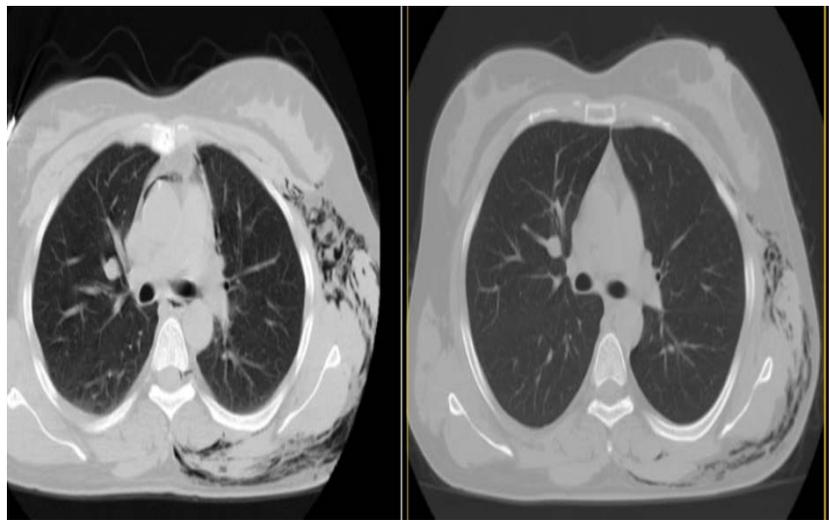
Axial thoracic CT images demonstrating the evolution of subcutaneous emphysema and pneumomediastinum.
